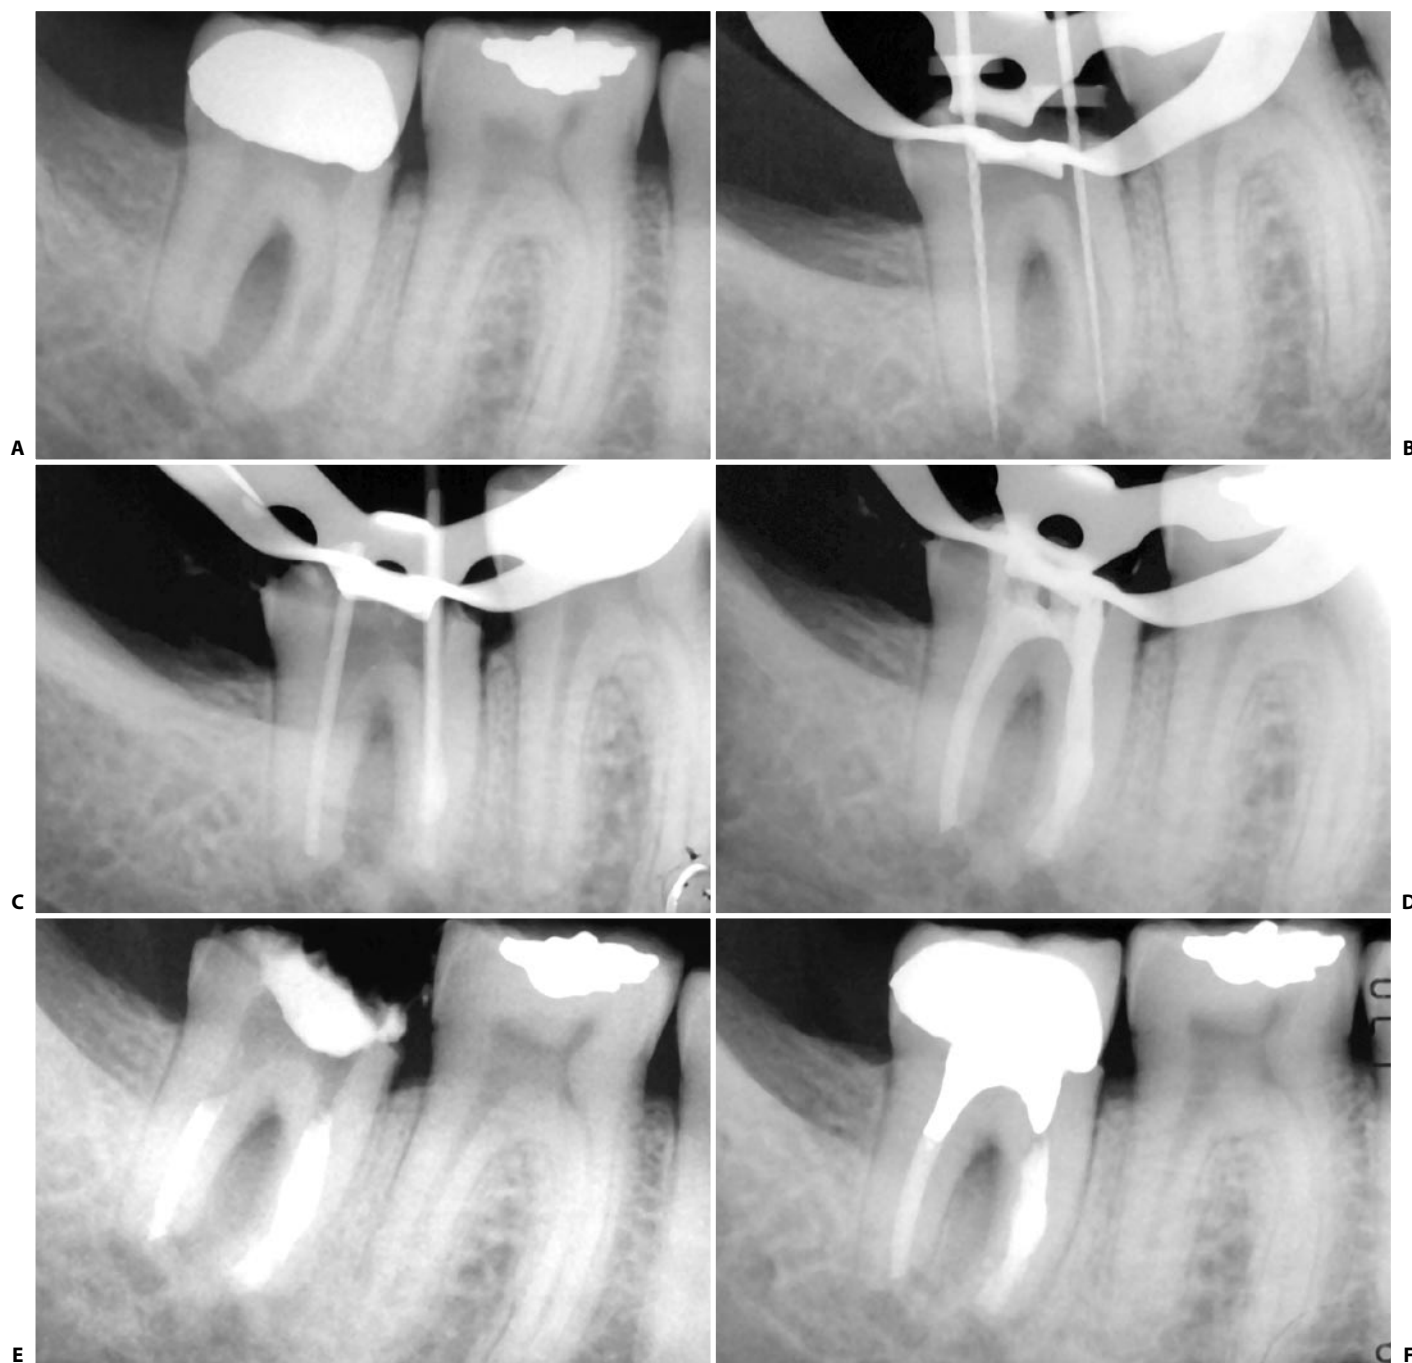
Endodontic treatment of lower second molar. A. Preoperative radiograph: the tooth has undergone a direct pulp capping which has failed with the formation of a large area of internal resorption close to the apex with damage to the endodontic anatomy. B. The endodontic instruments underline the altered canal path with apical resorption. C. Radiograph of cone fit. D. Postoperative radiograph: obturation carried out with Microseal Technique. E. Three month recall. F. Six month recall.
